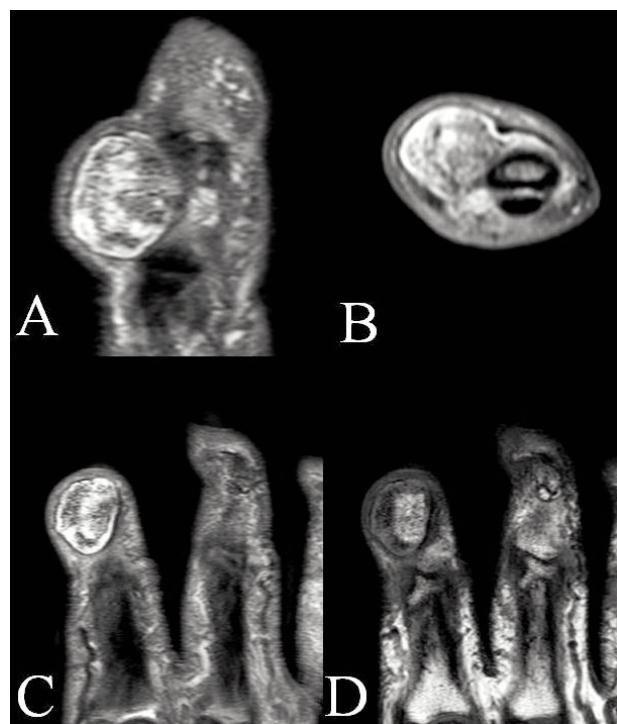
Magnetic resonance imaging – (A) PDW sagittal, (B) PDW axial, (C) PDW HR coronal and (D) T1W coronal images – non-homogeneous oval lesion with thin non-signal surface layer attached to a medial phalanx of the second finger of the right hand; its peripheral and radial part is mostly hypointense on both T1- and PD-weighted images, its central and ulnar part is mostly hyperintense on both T1- and PD-weighted images; no signs of cortical or medullar involvement of the underlying phalanx
